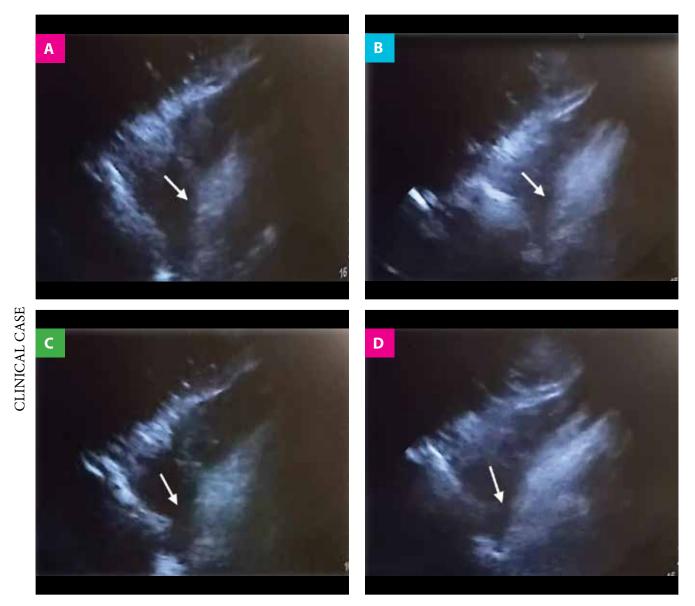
Echocardiogram (17.XII.17). Image A, B, CYD: Pericardial effusion of approximately 250cc (prepericardio centesis) with hemodynamic compromise, dilated left ventricle with right ventricle collapse (white arrow). Shunts are not appreciated. No significant valvular rations.
